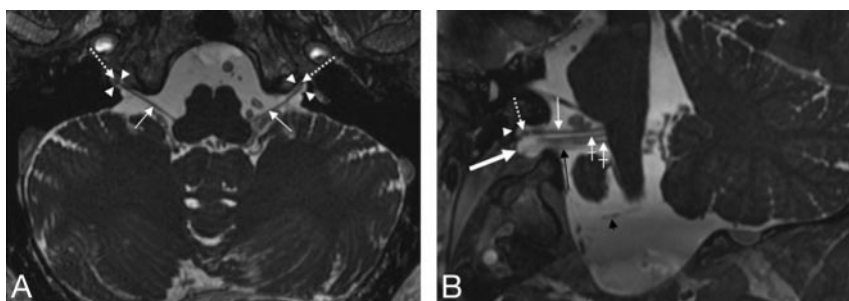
Visualization of the supCNIX. Axial (*A*) and oblique sagittal (*B*) 3D-FIESTA MR images. *B*, The oblique sagittal image is reconstructed parallel to the cisternal course of the lower CNIXs. Nerve root bundles of CNIX (*thin white arrows*), CNX (*crossed white arrows*), crCNXI (*black arrow*), and CNXII (*black arrowhead*) and the glossopharyngeal meatus (*white arrowhead*), vagal meatus (*thick white arrow*), and the supCNXI (*dotted white arrows*) are depicted.
